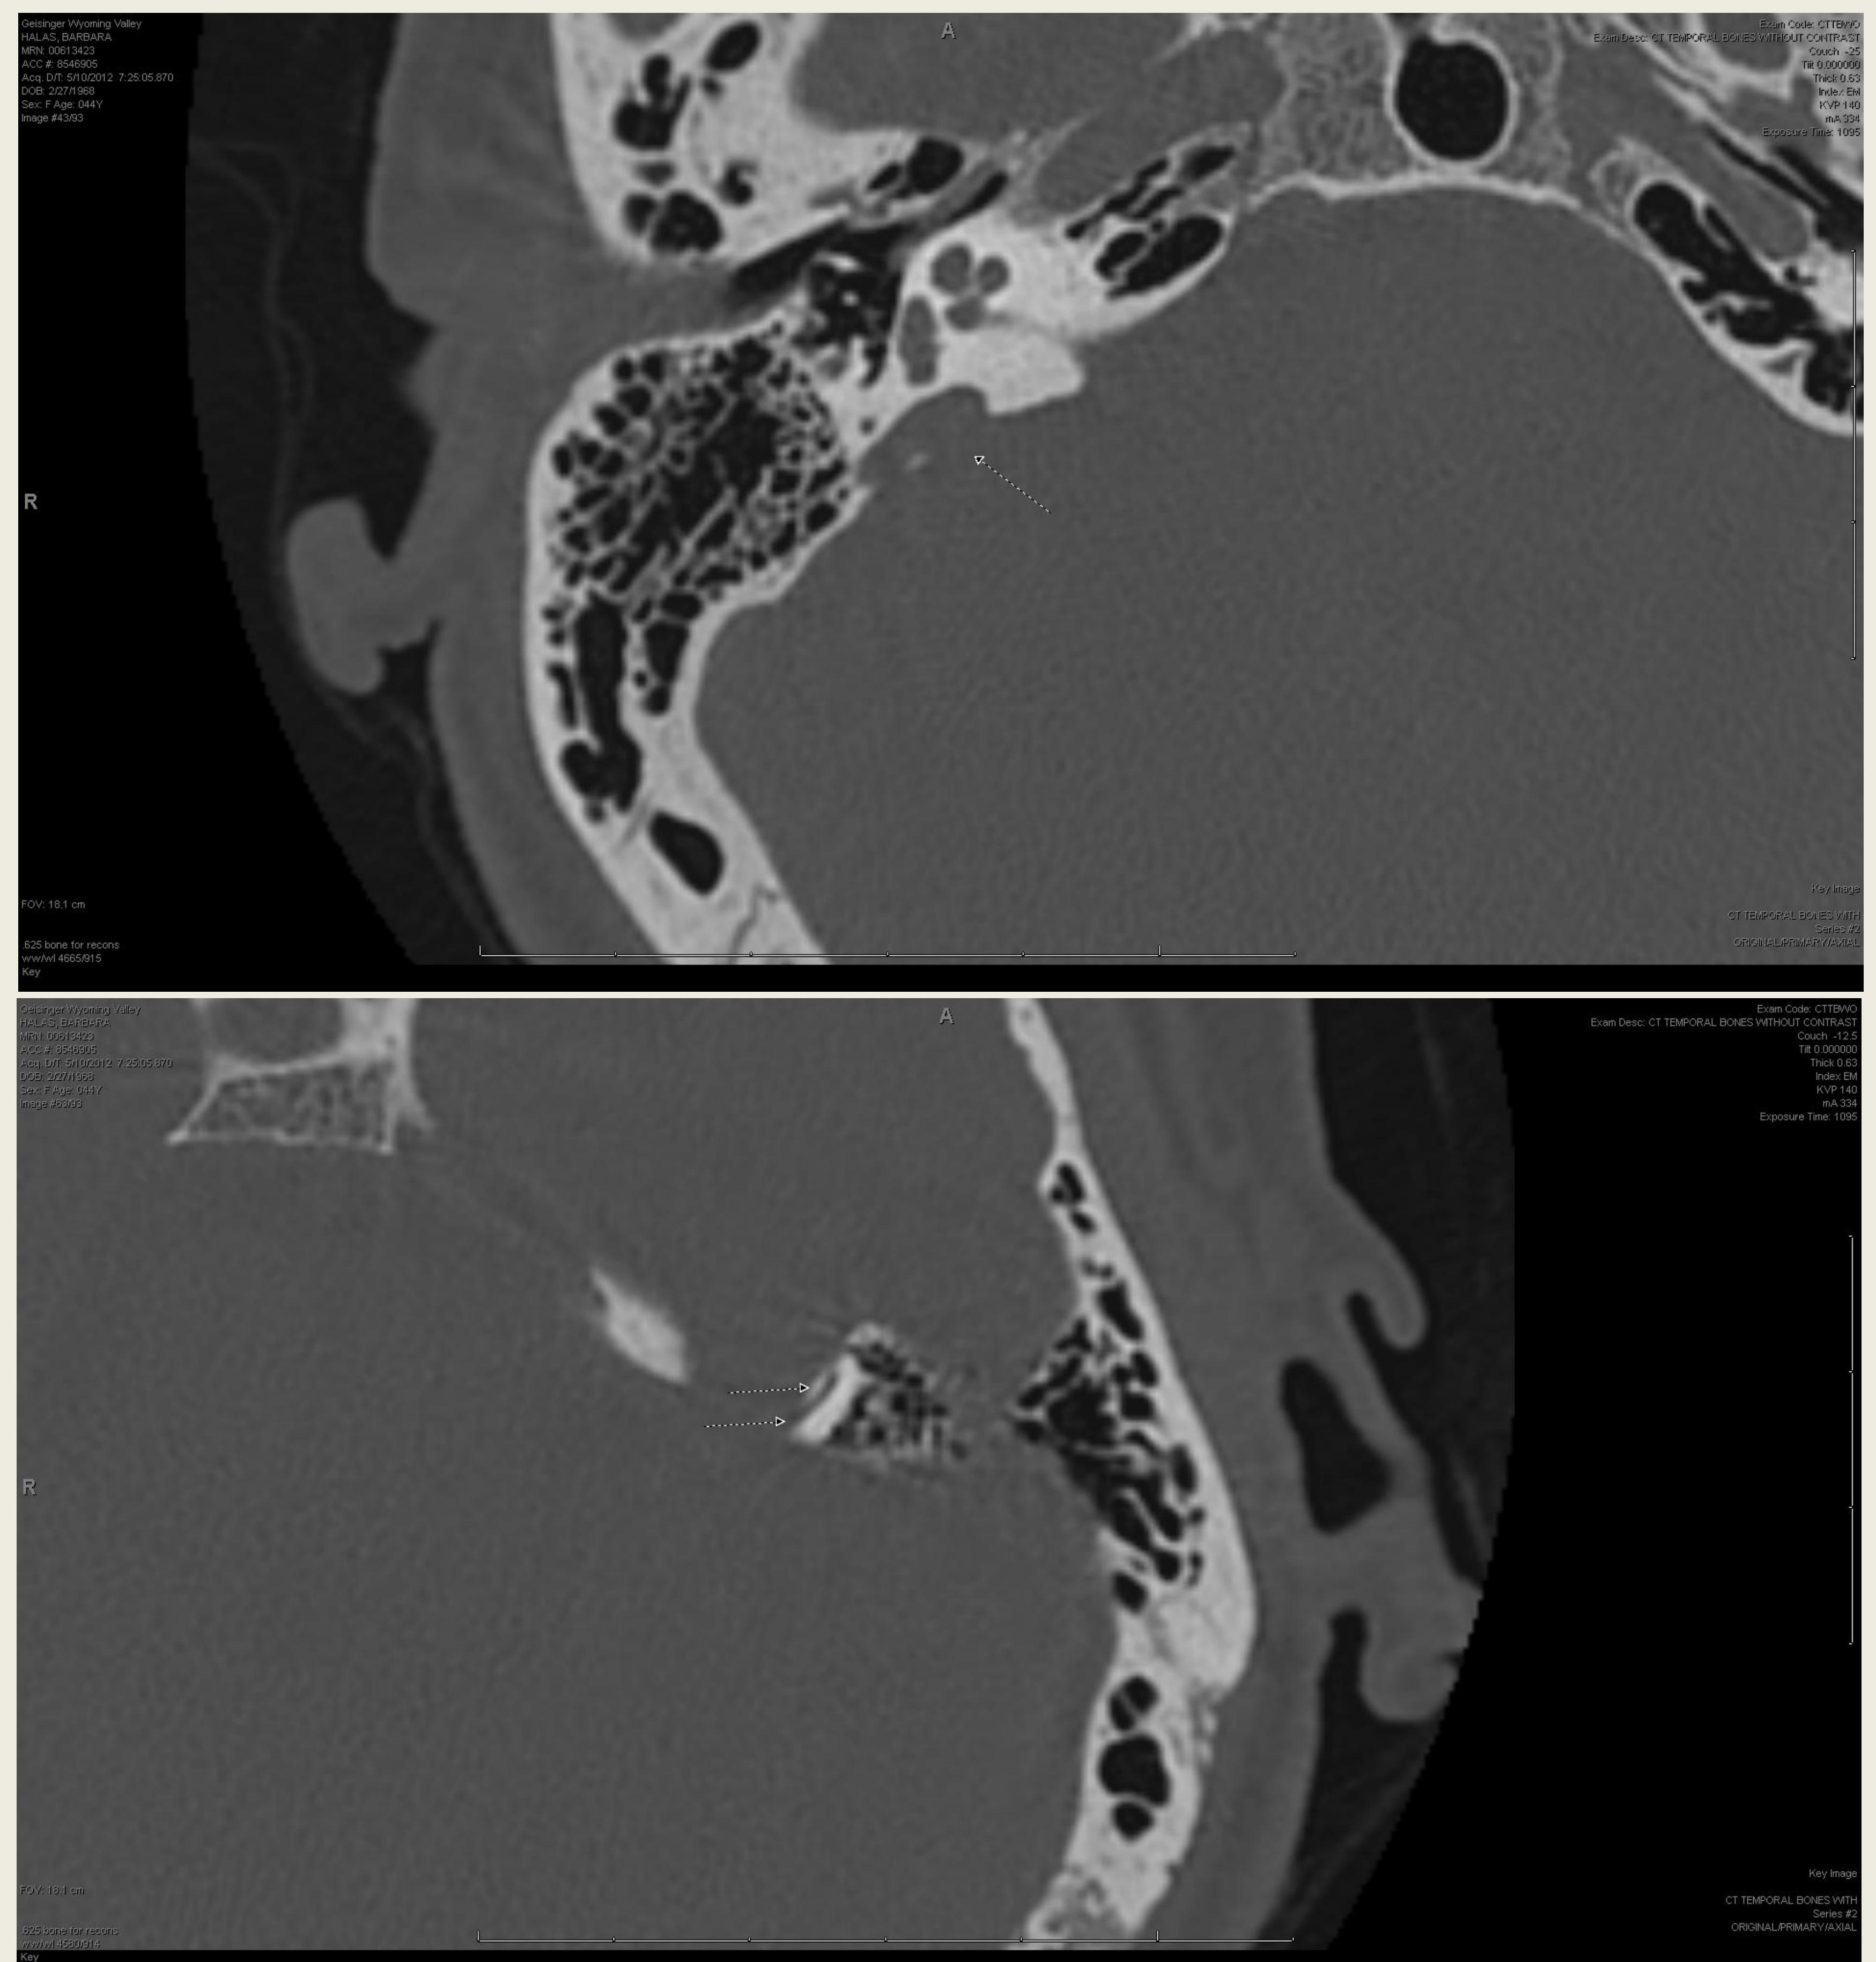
CT Temporal bone showing left sided enlarged vestibular aqueduct
